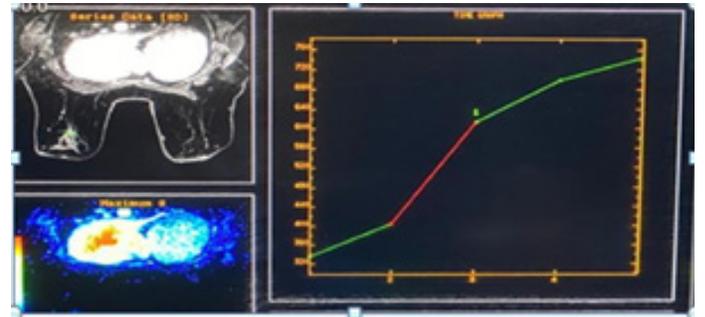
MRI time-intensity kinetic enhancement curve shows persistent- type I curve. Biopsy was consistent with fat necrosis, with areas of fibrosis—indicative of fat necrosis in Late stage
